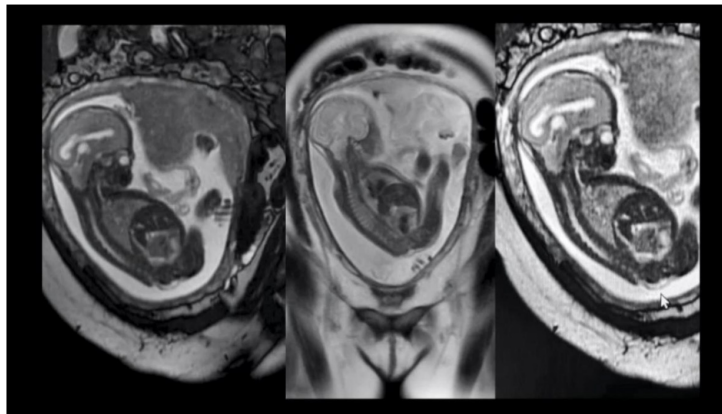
Pelvic MRI for the diagnosis of MMC
